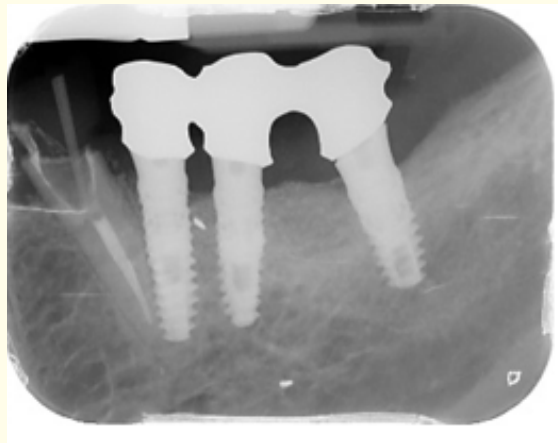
The initial x-ray with the extremely compromised first premolar
